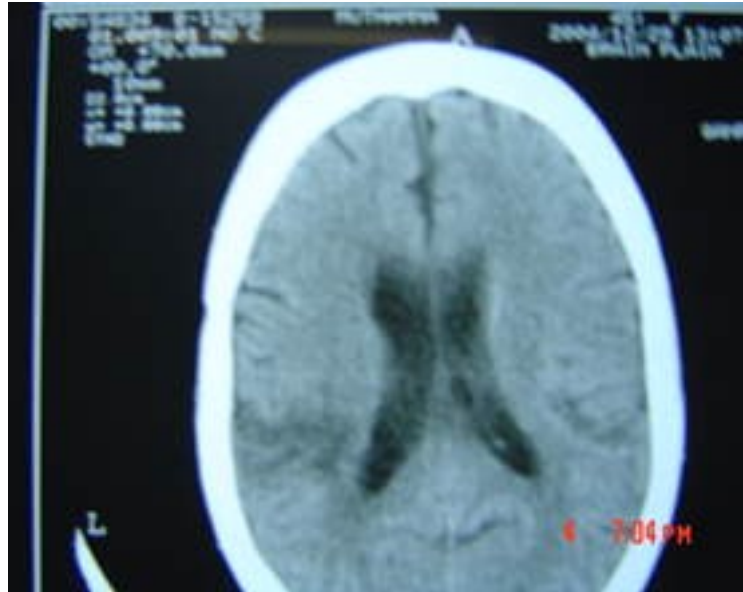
d. CT SCAN OF A PATIENT WITH CONDUCTION APHASIA
